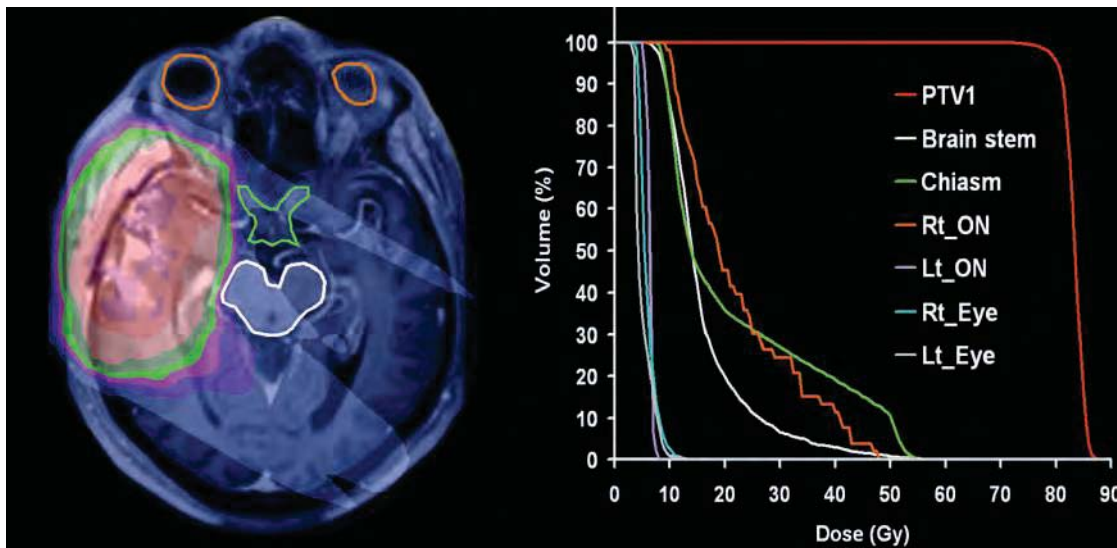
Resulting isodose distribution for an optimized intensity-modulated brain treatment. Dose-intensity pattern in the *left panel* is overlaid on the patient's magnetic resonance images used in planning. Also contoured are the optic chiasm (*green*), the brain stem (*white*), and the eyes (*orange*). In the *right panel*, the dose distribution throughout all slices of the patient's anatomy is summarized via cumulative dose-volume histograms for the various tissues and volumes that have been previously segmented. Each location on each curve represents the fraction of the volume of that tissue (%) that receives greater than or the same as the corresponding dose level.
